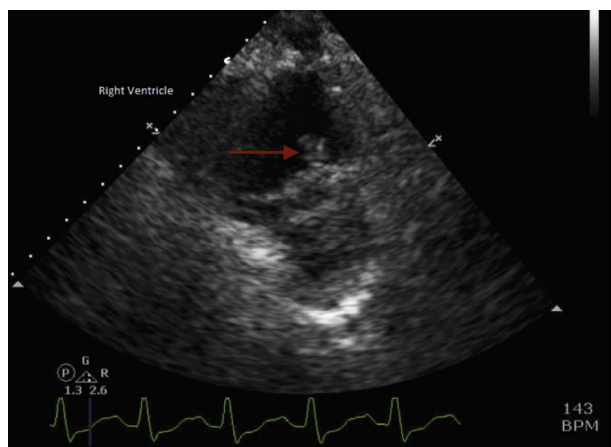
Sonogram of the heart (short axis) showing thrombus in right ventricle along with right heart strain (arrow).
